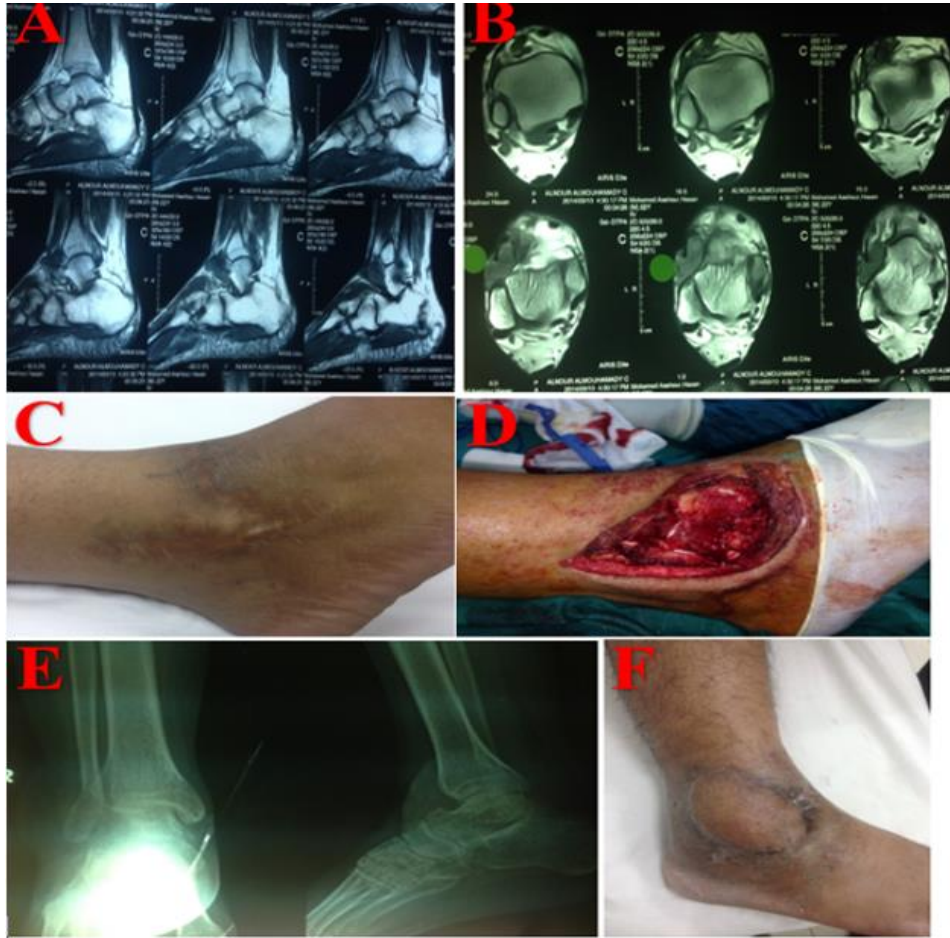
A case of 35-year-old male with myxoid fibrosarcoma ankle and foot. The mass was excised several years before presentation and no pathology was done. A-B: Pre-operative radiographs showed enhanced signal and nodules in the operative bed. C: previous operative scar. D: operative bed after adequate resection. E: post-operative radiographs. F: healed sural flap. The patient remained disease-free for 5 years post-operative
